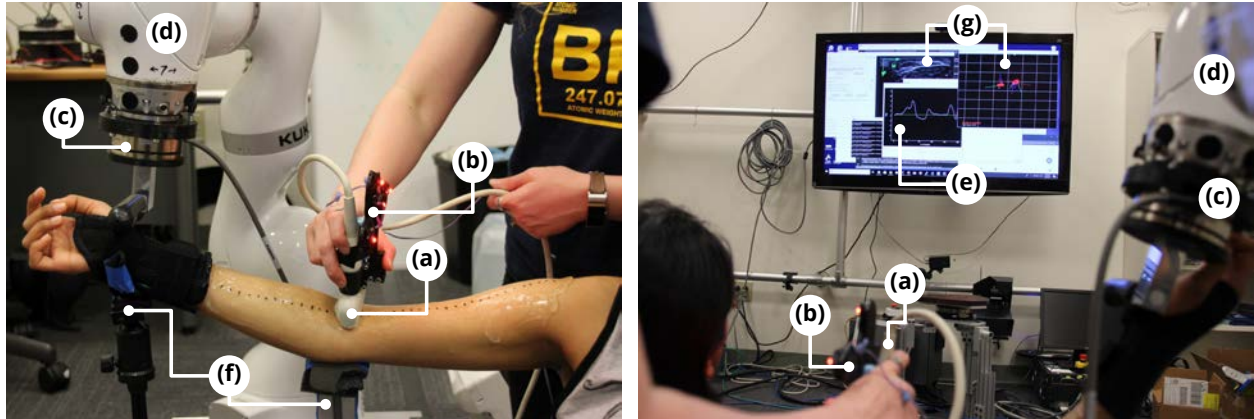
Experimental setup for the collection of OpenArm 2.0 full-arm upper-limb morphology data under multiple elbow angles and loading conditions (shown here at a 30° angle of elbow flexion under FS (*left*) and P1 (*right*) loading conditions). Setup includes ultrasound probe (a) (with attached active motion capture markers (b) used for spatial tracking); force-torque sensor (c), held statically in place by KUKA LBR iiwa 14 R820 robot (d) and used by the subject via real-time visual feedback (e) to maintain constant force output during loaded trials; mechanical jig (f) used to support the elbow (during all trials) and the forearm (during FS trials, *left*); and real-time ultrasound and motion capture data (g) for continuous system status monitoring. ©2019 IEEE.
